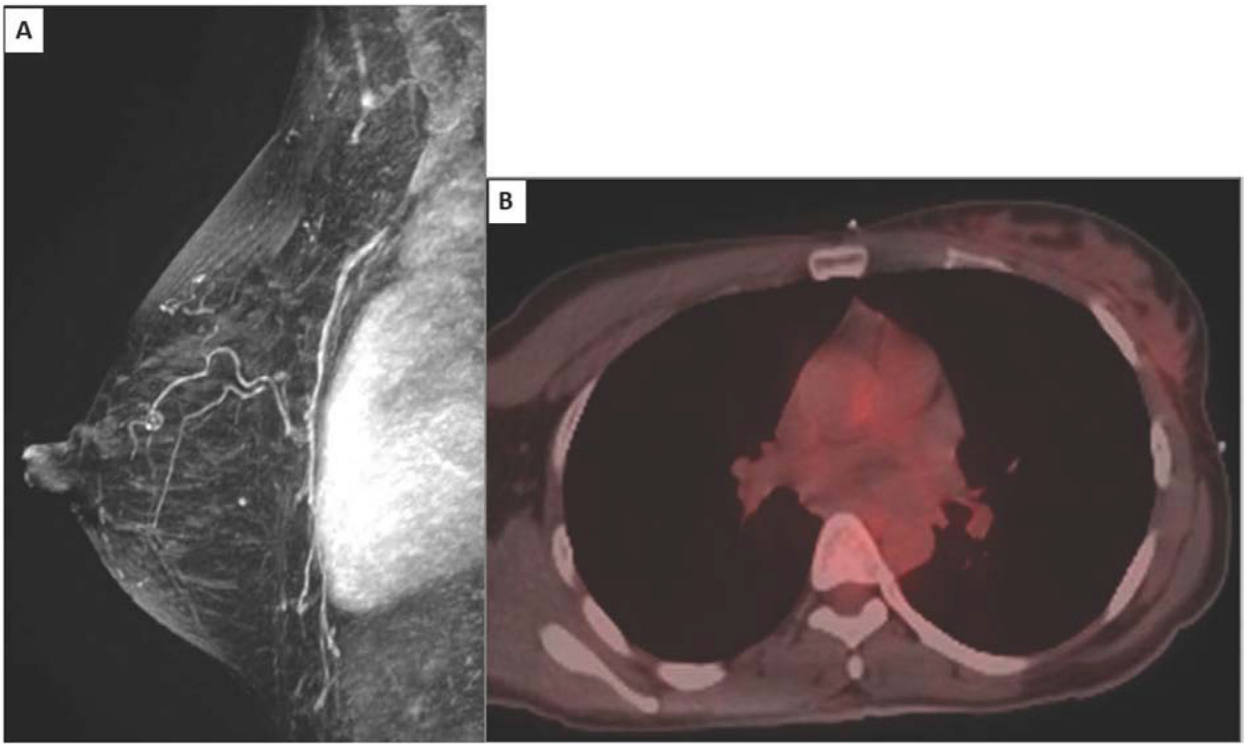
Case 1, post-treatment. (A) Subtraction maximum intensity projection (MIP) image from breast magnetic resonance imaging (MRI) after chemoradiation shows resolution of lymphomatous masses. (B) Post-treatment positron emission tomography/computed tomography (PET/CT) following three cycles of chemotherapy demonstrates that the previous foci of fluorodeoxyglucose (FDG) avidity are substantially diminished in activity.
